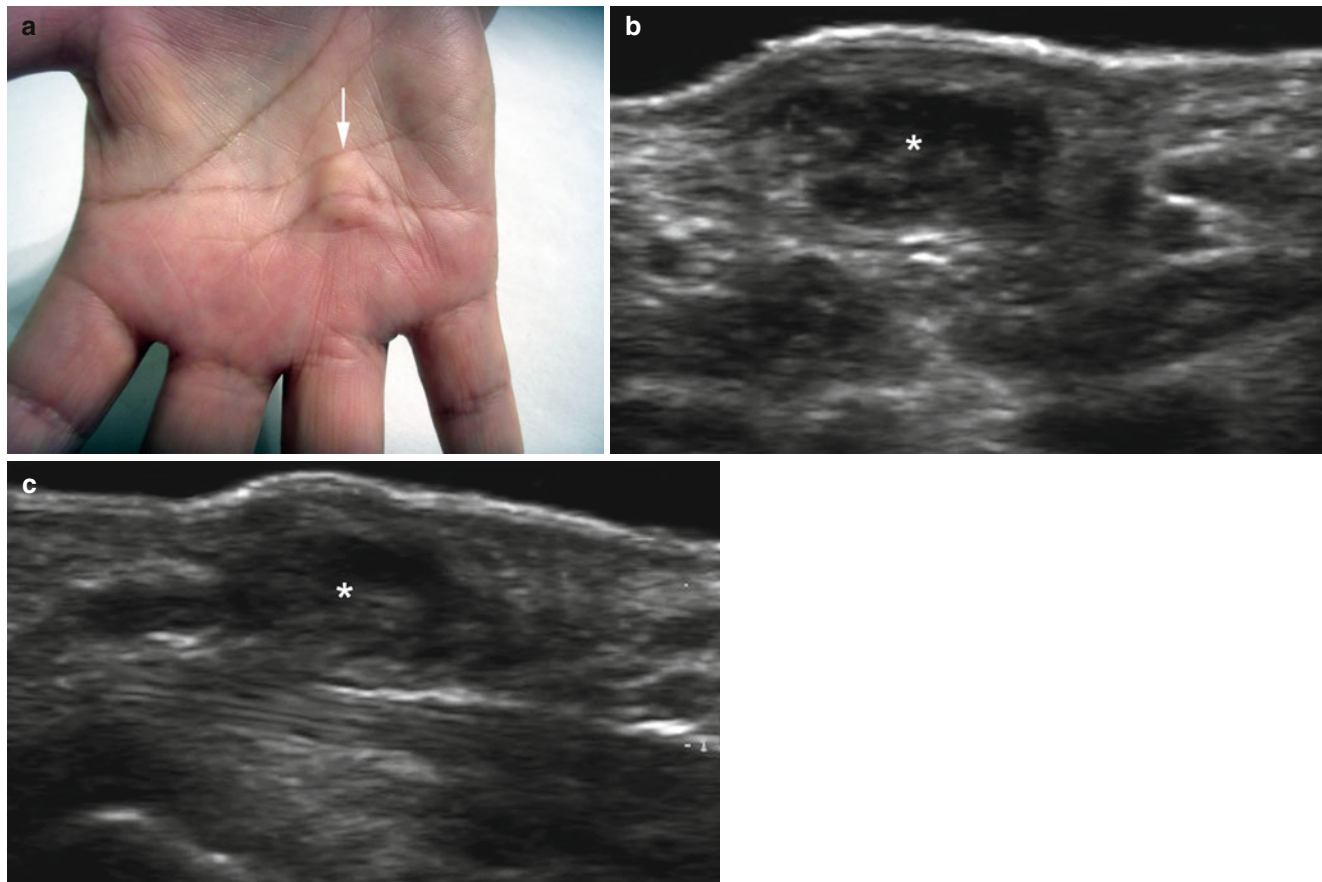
(a–c) Palmar fibromatosis-Dupuytren's disease. (a) Clinical image demonstrates a lump (*arrow*) in the palmar aspect of the right hand. (b, c) Grey scale ultrasound images (b transverse view; c longitudinal view) show a hypoechoic and heterogeneous solid structure (*) that follows the palmar fascia
